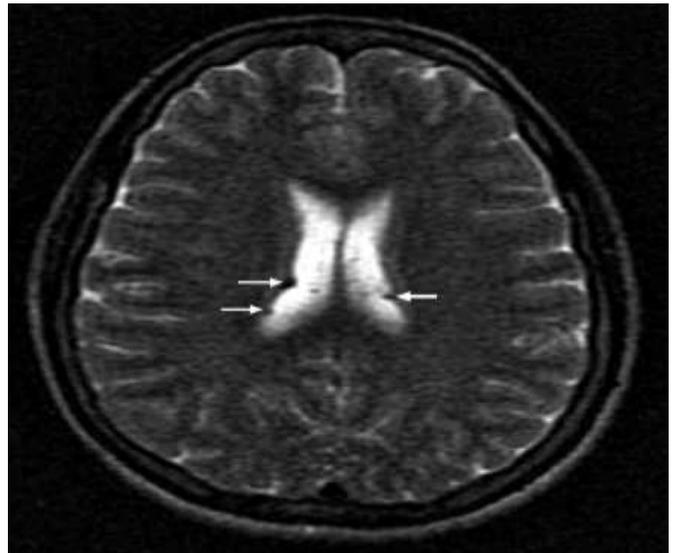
Axial T2-Weighted brain MRI showing multiple subependymal hypointense foci (arrows) due to subependymal tubers in the walls of the lateral ventricles.
